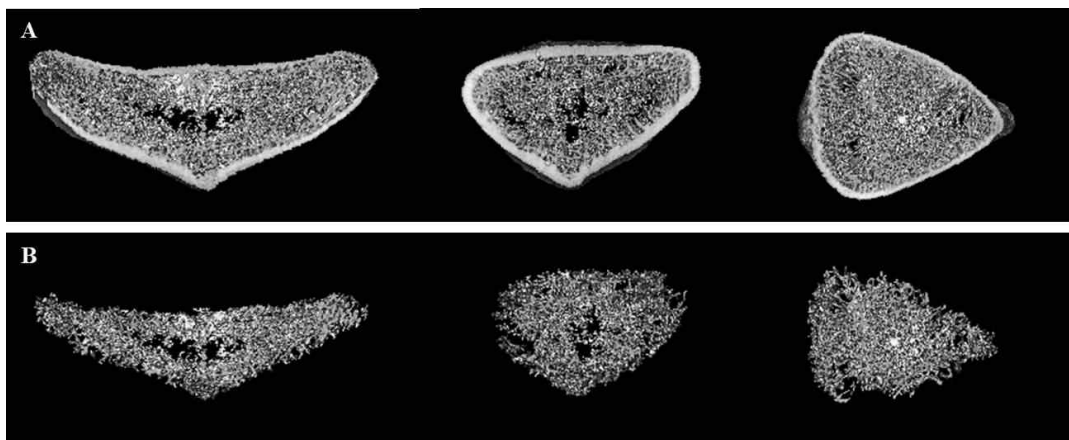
Micro-positron emission tomography/computed tomography images of the sternum. A: Total bone, B: Trabecular bone.
